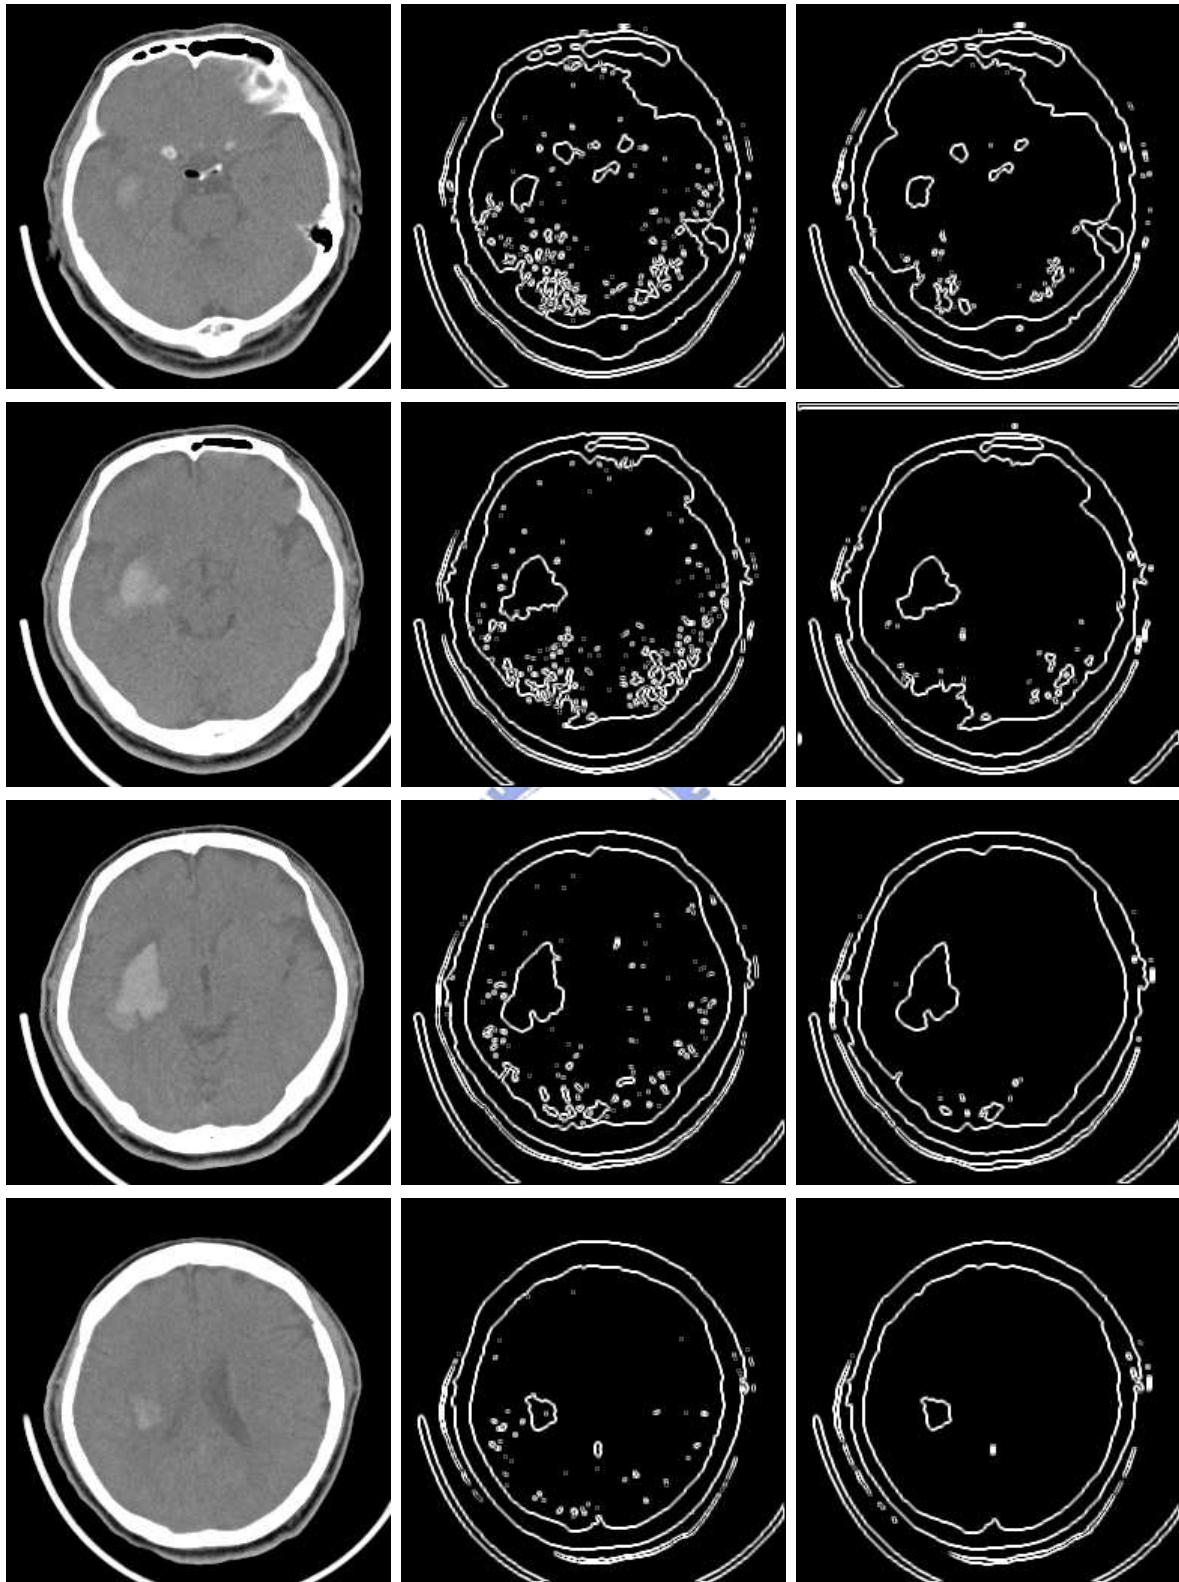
We partitioned the pixels in the CT images into 2 sets. We then calculated the boundaries for the pixels in the same set. The images in the first column are the original images. Images in the second column were obtained by first applying mean filter to the original images then applying intensity thresholding. The images in the third column were obtained by the proposed method.
